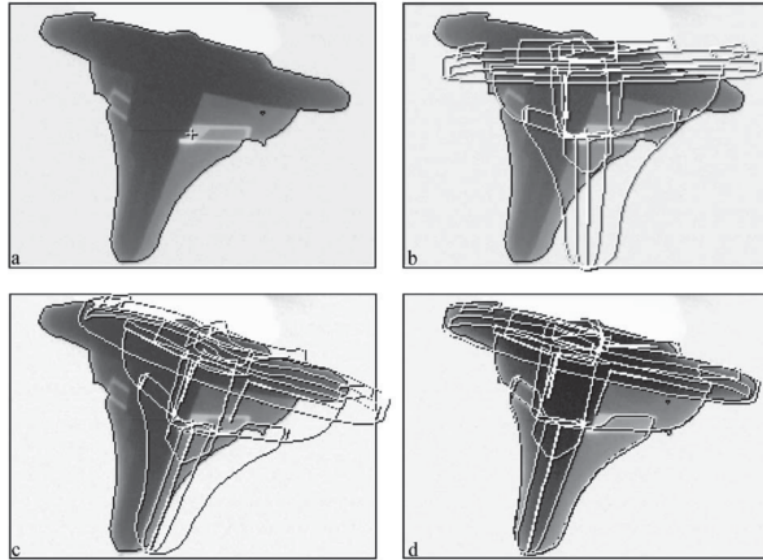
Matching the model of the implant (wire frame) to the x-ray image of the implant. [19]
